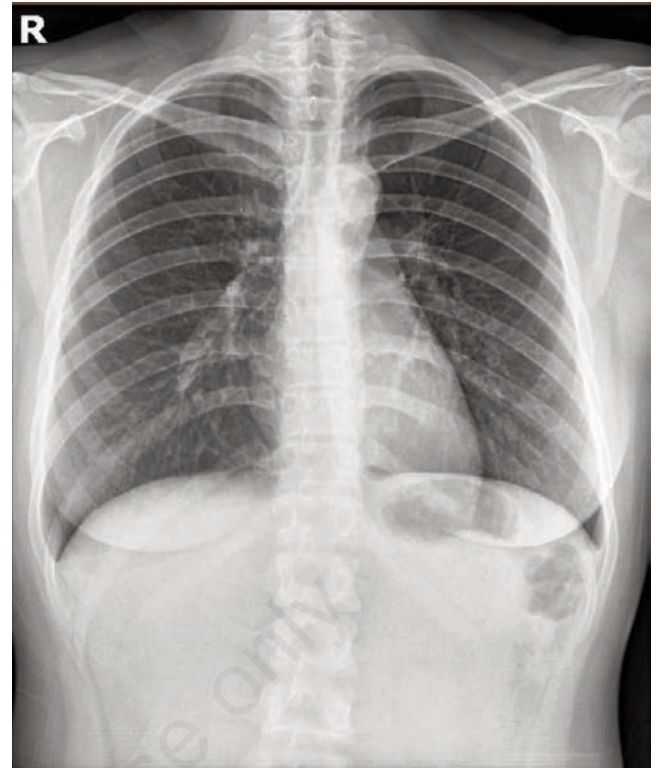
Chest X-ray 3 months after COVID-19 infection revealed no parenchymal abnormality.
